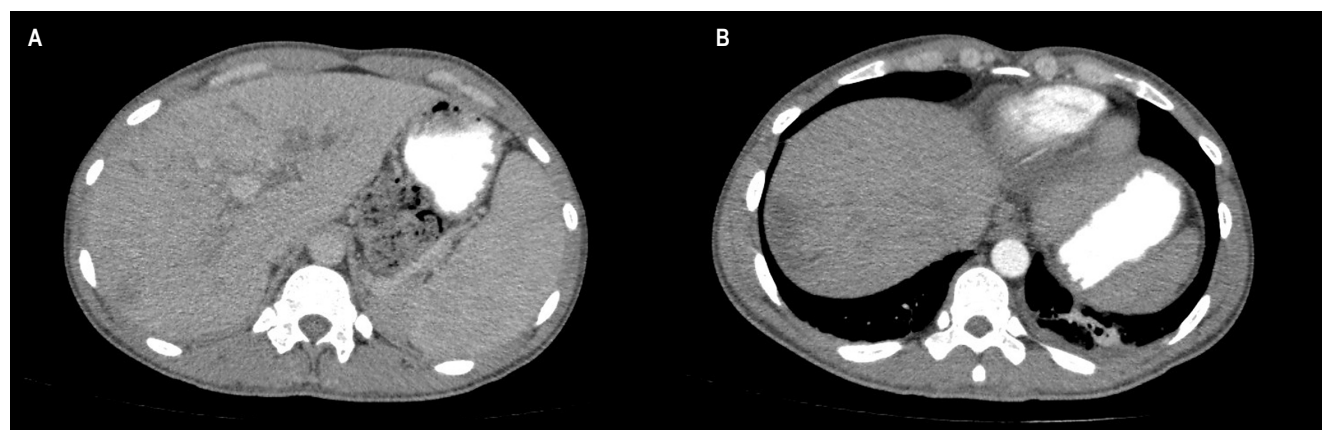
Contrast-enhanced computed tomography of the abdomen and pelvis. A. Peripheral caudal collection in segment VII measuring 19 × 19 × 16 mm (L × AP × T), consistent with a hepatic abscess, with an approximate volume of 8 mL. B. Additional collection in segment VII, located more superiorly and with poorly defined borders, measuring 57 × 59 × 31 mm, with an approximate volume of 54 mL. Thrombosis of the left portal vein and right portal branches. Heterogeneous enhancement of the hepatic parenchyma, predominantly during the arterial phase. Splenomegaly. Author's file.
